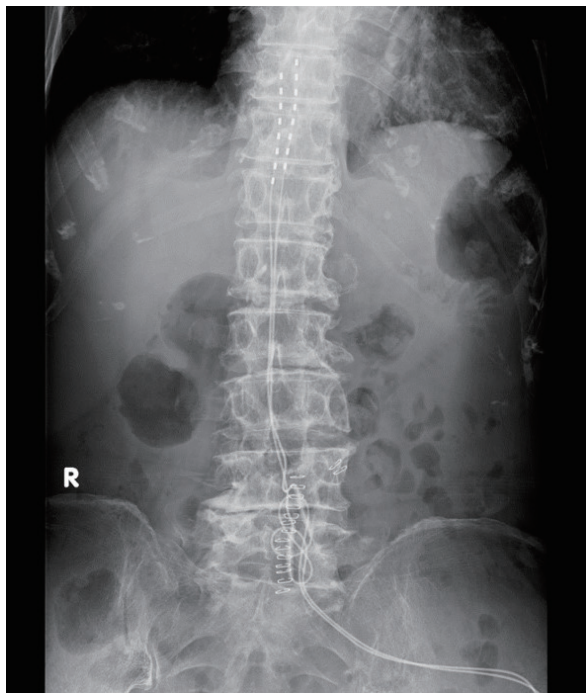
Radiography of the spinal cord stimulator. Two electrodes were placed in the posterior epidural space at the T10/11 level.
